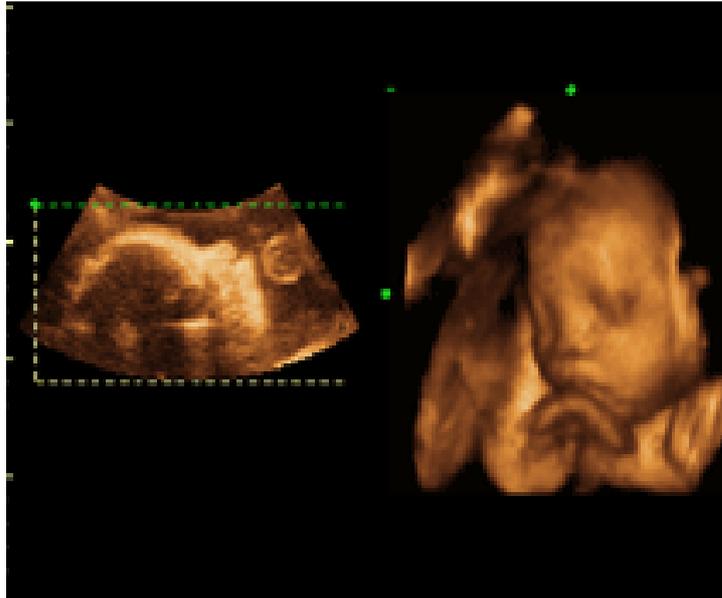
4D Ultrasonic-CT images of a baby in mother's womb [ Ref. 19 ]
